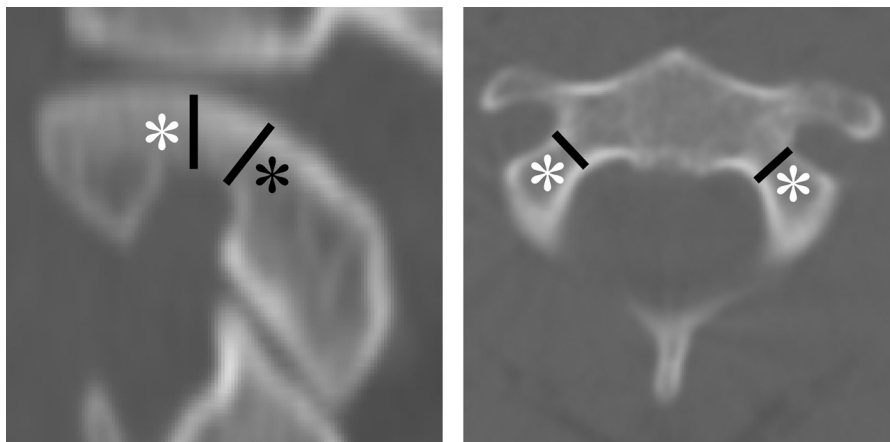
(Left) High-riding vertebral artery is defined by an isthmus height (black asterisk) of 5 mm or less and/or internal height (white asterisk) of 2 mm or less on a sagittal image that is at 3 mm lateral to the cortical margin of the spinal canal wall at C2. (Right) Narrow pedicle is defined by a pedicle width (white asterisk) 4 mm or less, which is measured on axial computed tomography scan images at the levels where the lateral cortical margin of the pedicle was clearly seen.
